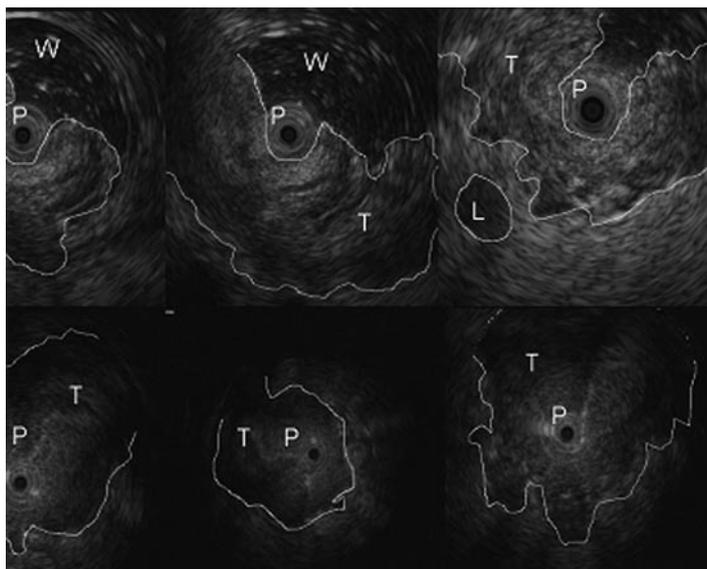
Stage T4 rectal cancer: Miniprobe ultrasonographic view. Endoscopic ultrasound with radial miniprobe (12 MHz) shows an advanced, stenotic rectal cancer with large hypoechoic and inhomogeneous thickening of the rectal wall, loss of the five-layered wall structure and invasion of adjacent organs. T: Tumor; P: Miniprobe; L: Metastatic lymph node; W: Water.
